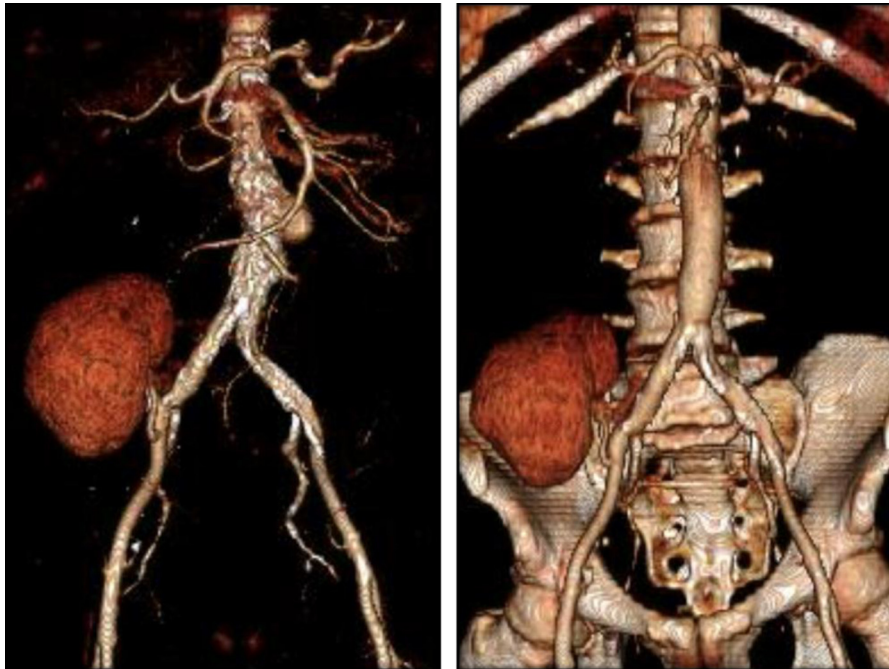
A three-dimensional computed tomography angiography reconstructions demonstrate a saccular infrarenal abdominal aortic aneurysm (left) before and (right) after complete excision of the infrarenal aorta and in-line reconstruction with cryopreserved human aortic allograft.
